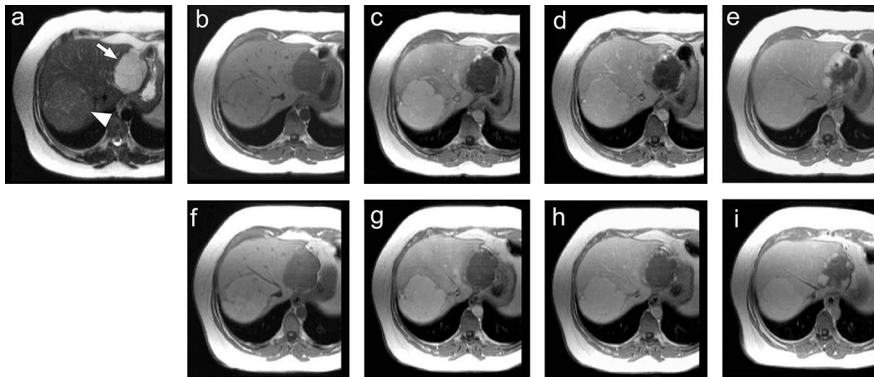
Atypical FNH and hemangioma in a 42-year-old female patient. The unenhanced T2-weighted image (a) reveals a large, strongly hyperintense lesion (arrow) in liver segment II and a faintly hyperintense lesion (arrowhead) in liver segments VII and VIII. The corresponding unenhanced T1-weighted image (b) reveals these lesions as markedly hypointense and isointense, respectively, against the surrounding normal parenchyma. During the dynamic series of acquisitions at 25 seconds (c), 60 seconds (d), and 5 minutes (e) after the first injection of 0.05 mmol/kg gadobenate dimeglumine, the lesion in segment II demonstrates an initial nodular peripheral enhancement followed by a centripetal “filling-in” pattern of contrast enhancement typical of hemangioma. Conversely, the lesion in segments VII and VIII shows rapid strong hyperintensity during the arterial phase (c) followed by contrast agent pooling during the portal-venous phase (d) and an isointense appearance during equilibrium (e) phase. Unlike the FNH in Figure 4, there is no evidence of a central scar in the lesion in segments VII and VIII. On the delayed phase image (f), the hemangioma is once again hypointense due to the wash-out of contrast agent while the FNH is faintly hyperintense to the surrounding normal parenchyma as the result of the specific uptake of gadobenate dimeglumine by the functioning hepatocytes present in FNH. Both lesions demonstrate similar enhancement patterns during a second dynamic series (g, h, and i) acquired after a second injection of 0.05 mmol/kg gadobenate dimeglumine.
